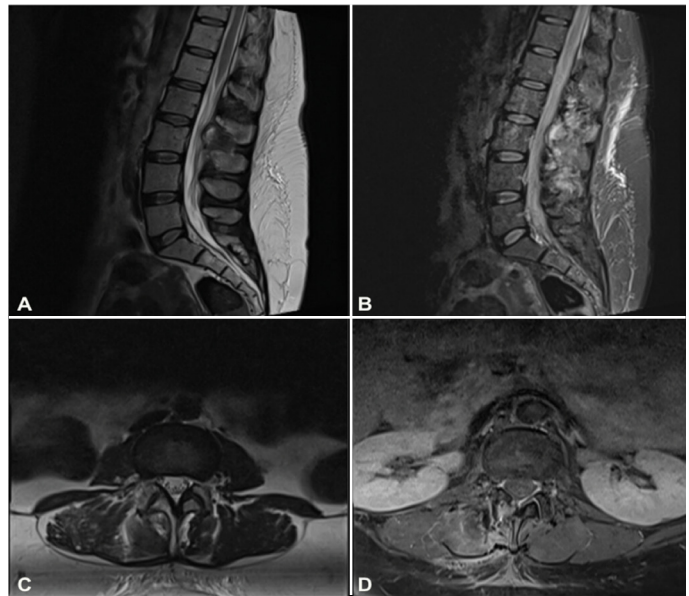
Magnetic resonance imaging obtained six weeks after the surgical procedure demonstrated a significant reduction of the expansile lesion, with complete resolution of its extension into the vertebral canal.
